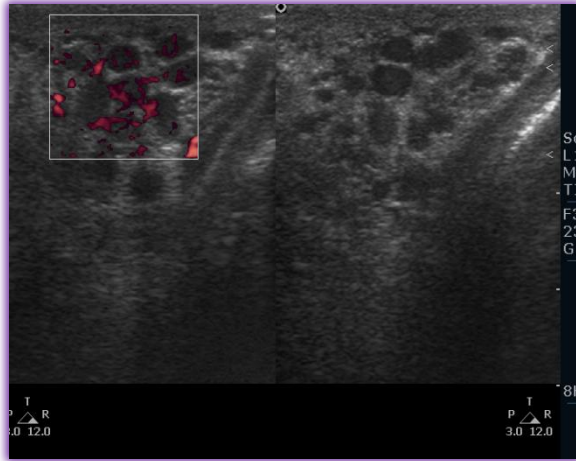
Transverse scan and power Doppler showing dilated pampiniform plexus of veins. (Case 44)
